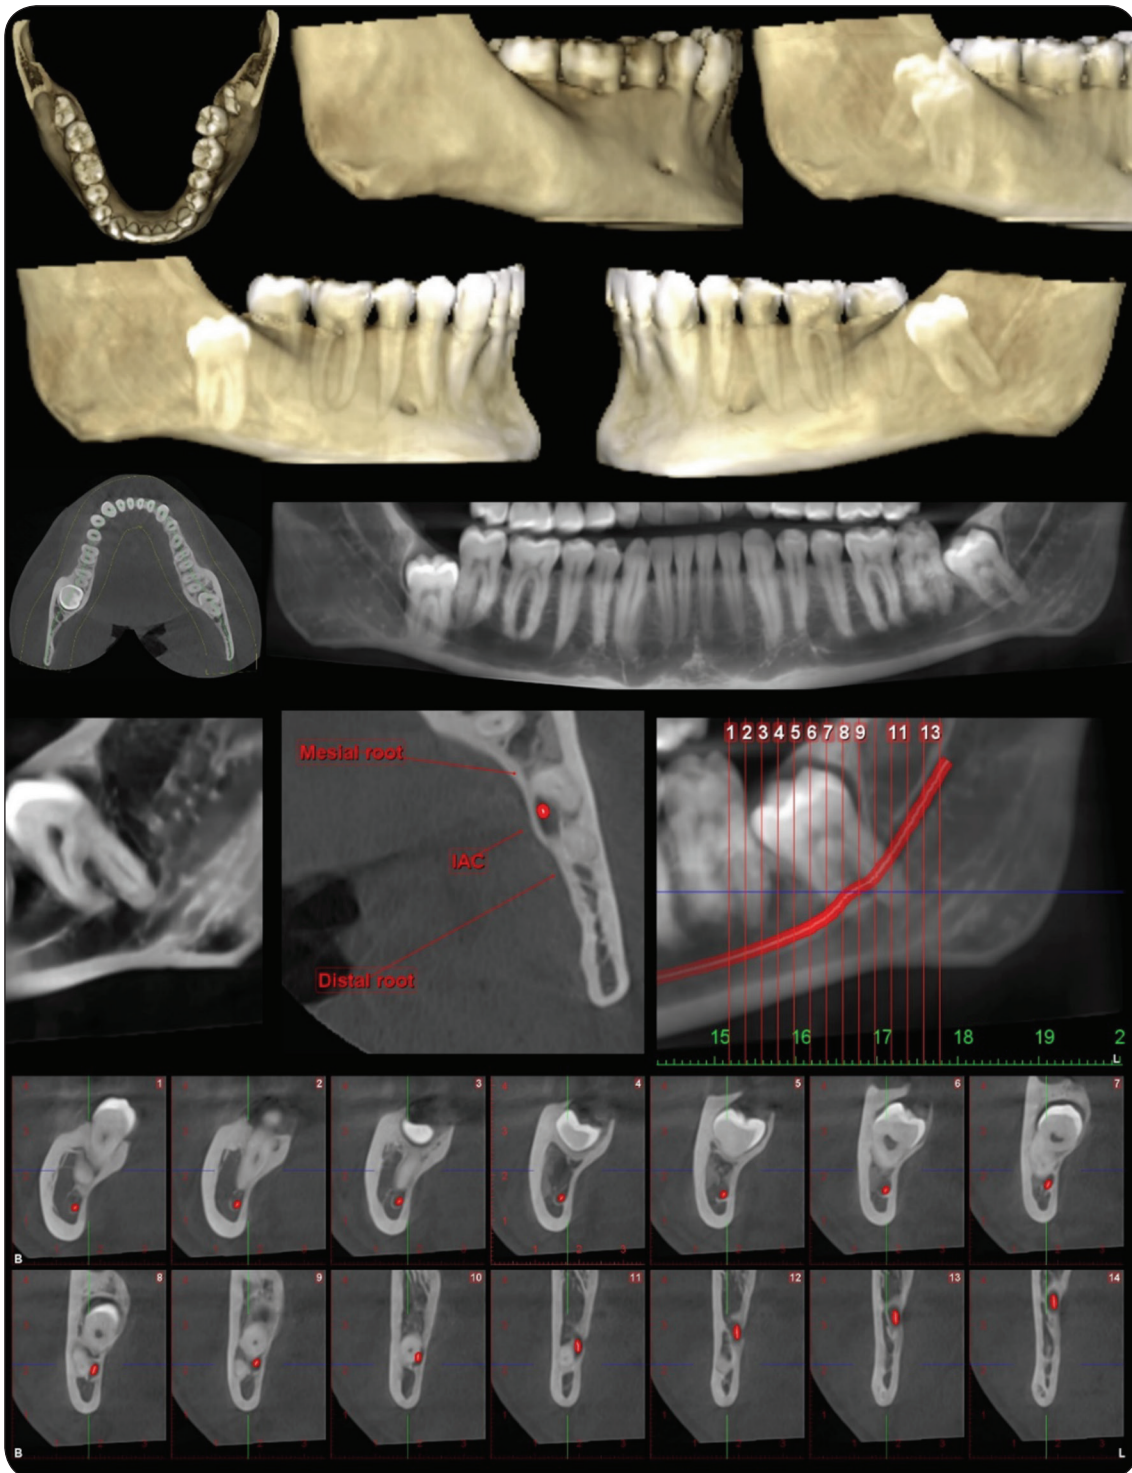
CBCT representing a case for bilateral impaction. Note: The superimposition of both third molars on volume rendering with increased transparency and how this superimposition was eliminated after segmenting the other side. Also, The clear appearance of root number in sliced panorama like view.
